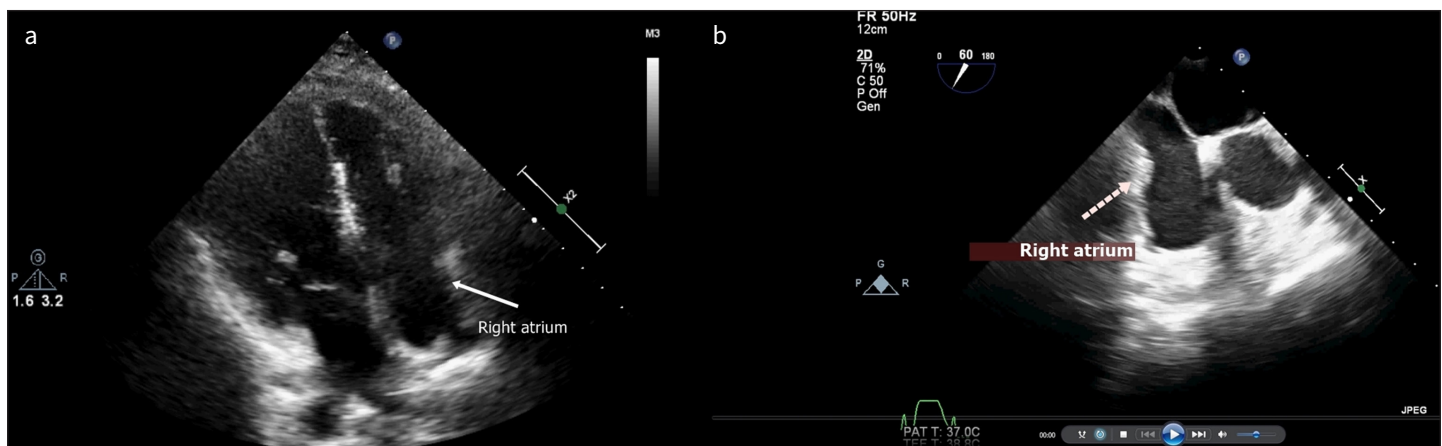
a, b. Transthoracic and transesophageal echocardiographic images showing complete resolution of atrial thrombus.
